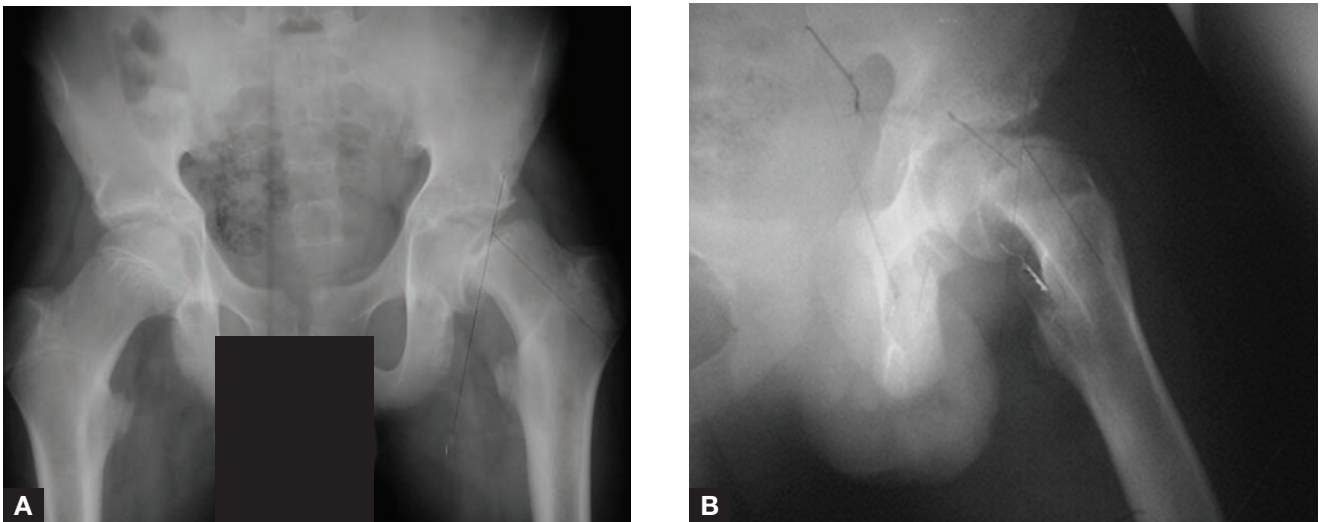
(A) Anteroposterior and (B) frog-leg lateral radiographs of pelvis and left hip, demonstrating severe slip of left hip.
